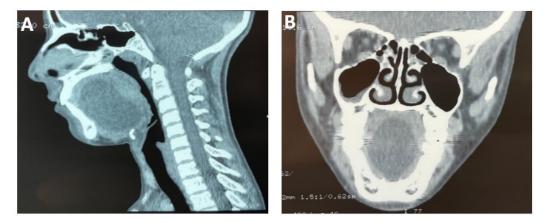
CT of sagittal view (A) and coronal view (B) demonstrates the left sublingual epidemoid cyst extended to the basal region of the tongue and compressing the oropharyngeal lumen measuring 55x30x55 mm.
